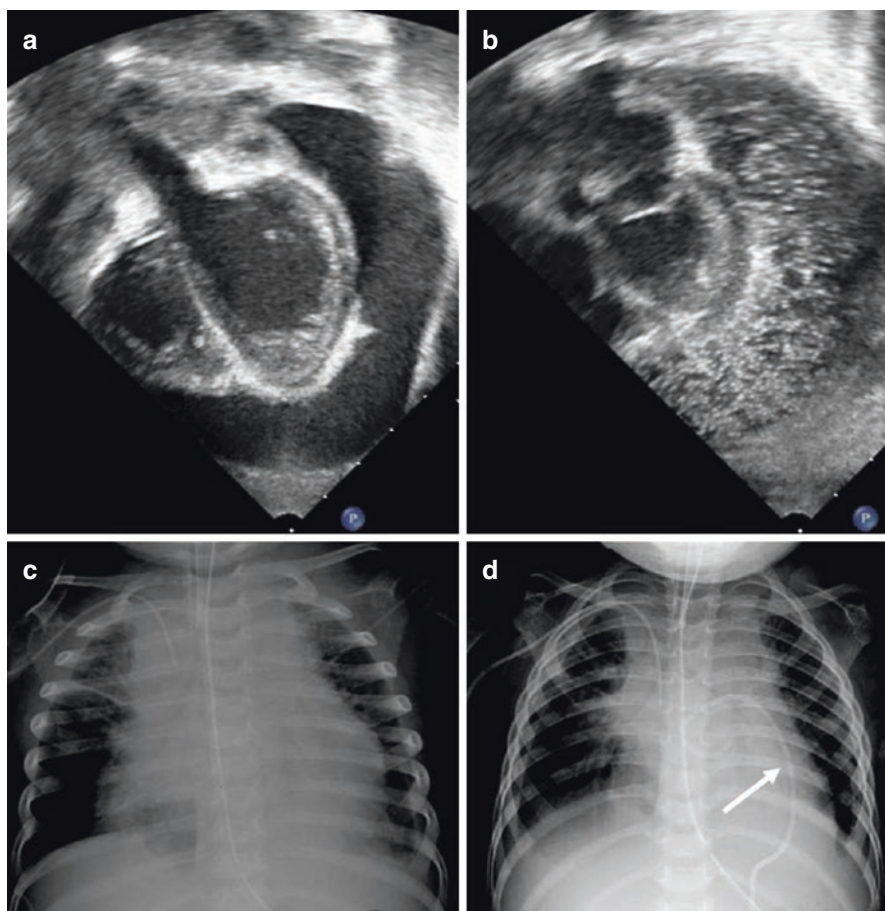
Pericardiocentesis and pericardial drain placement in a 3-year-old girl with bacterial pericarditis and large pericardial effusion. (a) Baseline transthoracic echocardiography shows a large, global effusion. There is an echo-bright tissue at the visceral pericardium. (b) Bubble study in the pericardial space: agitated saline is injected through the needle to the pericardial space, confirming the needle position. (c) Baseline chest radiography shows a large cardiopericardial silhouette. (d) Post-pericardial drain placement, chest radiography shows smaller cardiac silhouette and placement of pericardial drain (arrow)
